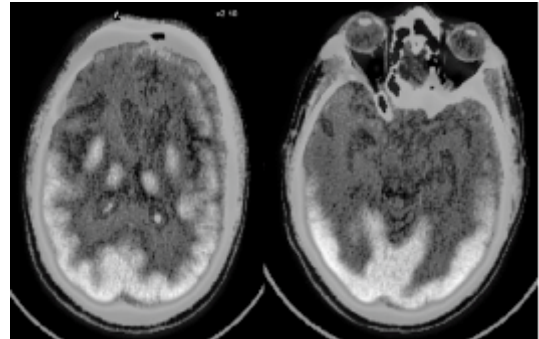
A classical case of fronto - temporal dementia : FDG PET/CT scan shows bilateral fronto -temporal hypometabolism.
